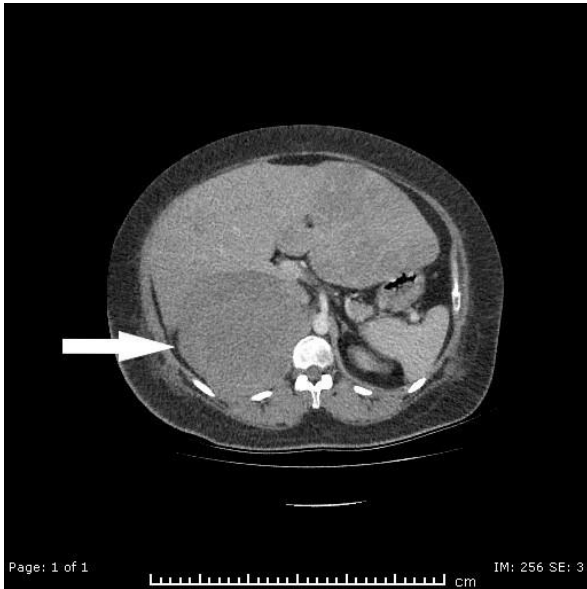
Contrast-enhanced CT image in the axial plane: Hypodense mass filling the right adrenal lodge and indenting the liver. Heterogeneously enhancing hypodense mass lesions in the liver parenchyma.
